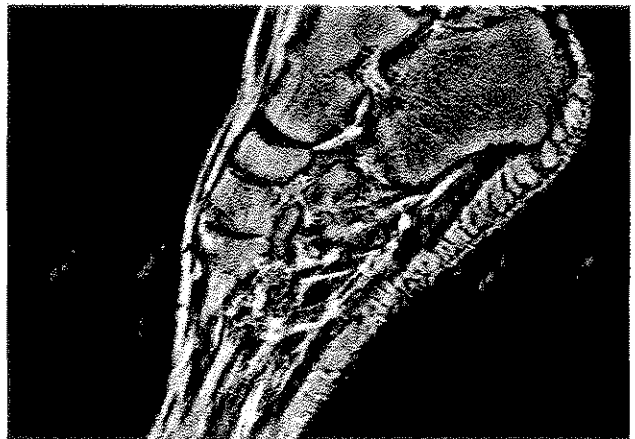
MRI scan of the foot: T₂-weighted sagittal image. Observe the area of bright signal intensity within the marrow adjacent to the margins of the third tarsometatarsal articulation (arrow). These signal alterations are consistent with BME (Courtesy of Dale G. Huntington).
